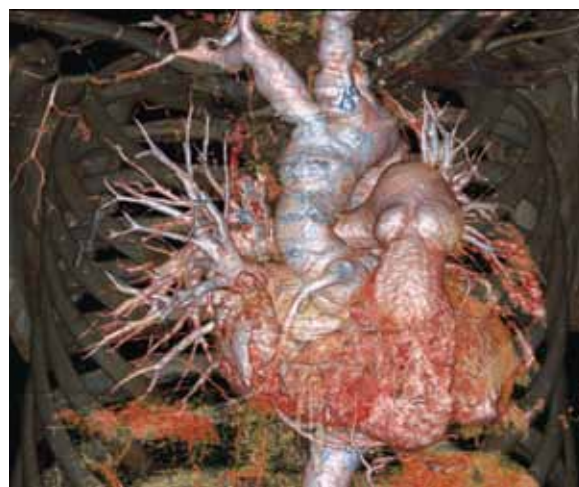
Postoperative CT of chest with intravenous contrast, 3D reconstruction
